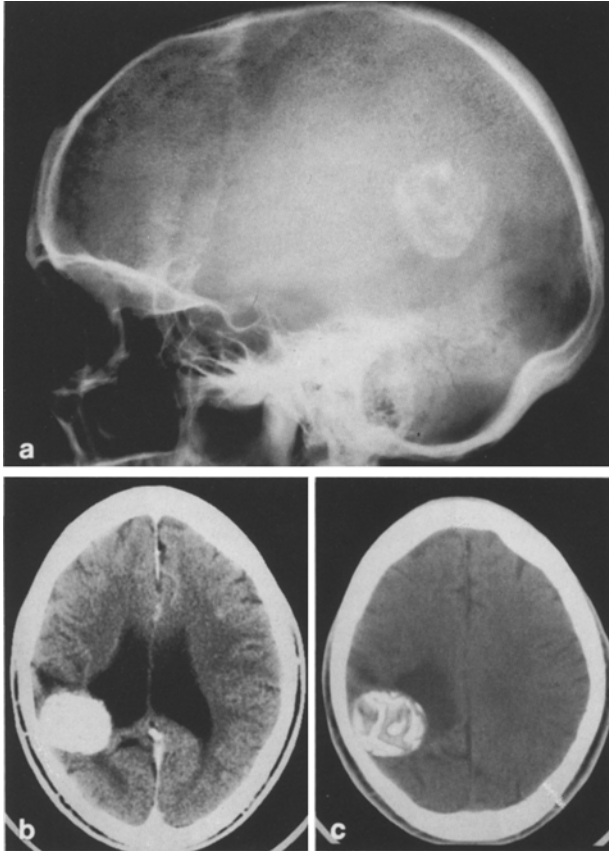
a-c. Case 6: Skull radiograph (a), contrast enhanced CT scan with standard (b) and plain CT with high window setting (c), show fairly round dense calcification with internal calcified bands and adjacent atrophy. Dilated lateral ventricles particularly the right which is also drawn towards the lesion. No enhancement seen on the contrast scan
